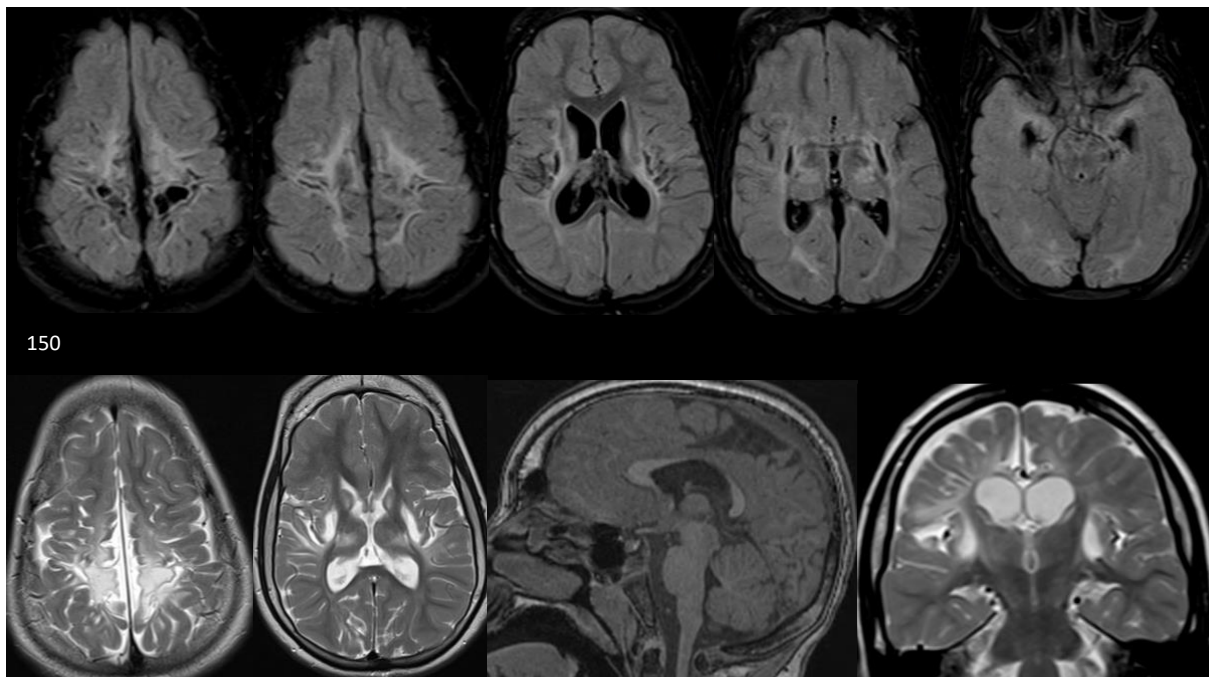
Collage of MRI images obtained for patient 150
